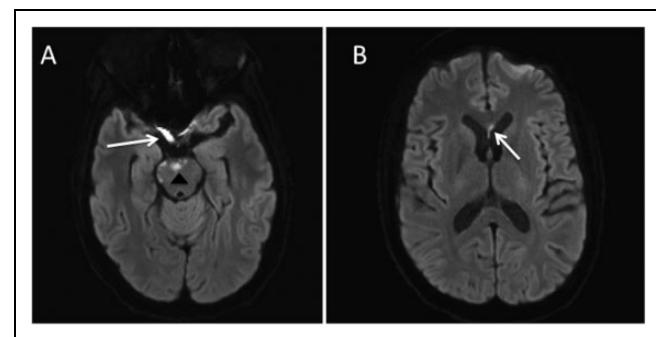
A, Axial diffusion-weighted magnetic resonance imaging (DW-MRI) demonstrates multifocal areas of restricted diffusion involving the pons (arrowhead) and right prechiasmatic optic nerve (arrow). B, There was additionally restricted diffusion in the corpus callosum (arrow).
